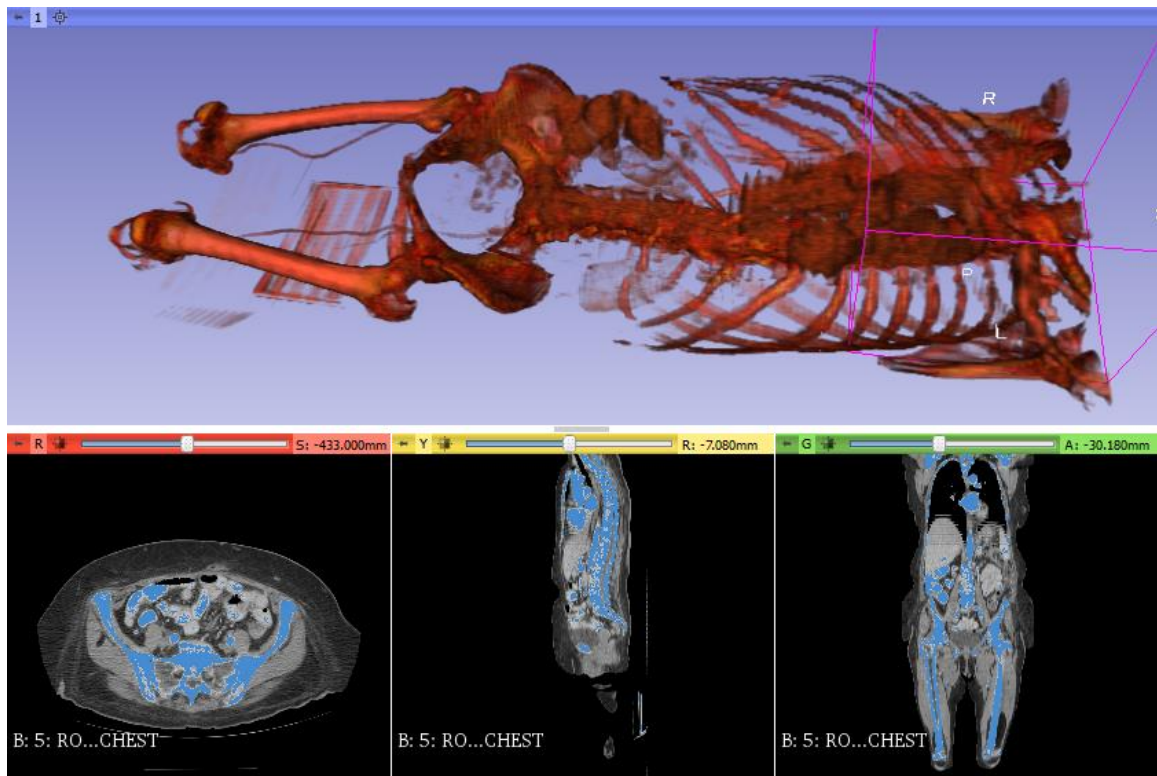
3D slicer in the Segmentation module. The 3D human models were shown in the upper in CT-Bone mode that was segmented from the CT data. And the CT data from TCIA was shown in the lower where the blue portion indicated the segmented area based on the threshold range.
